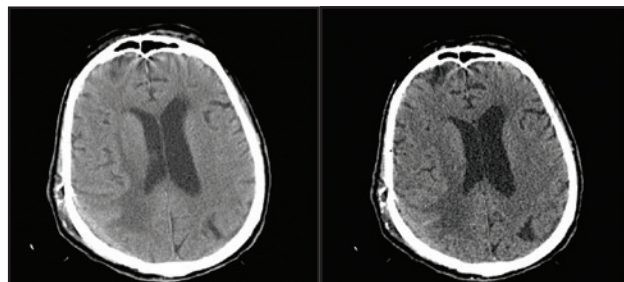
Cerebral CT scan native and with contrast agent, taken 14 days after surgery, indicates cerebral postsurgical modifications.
